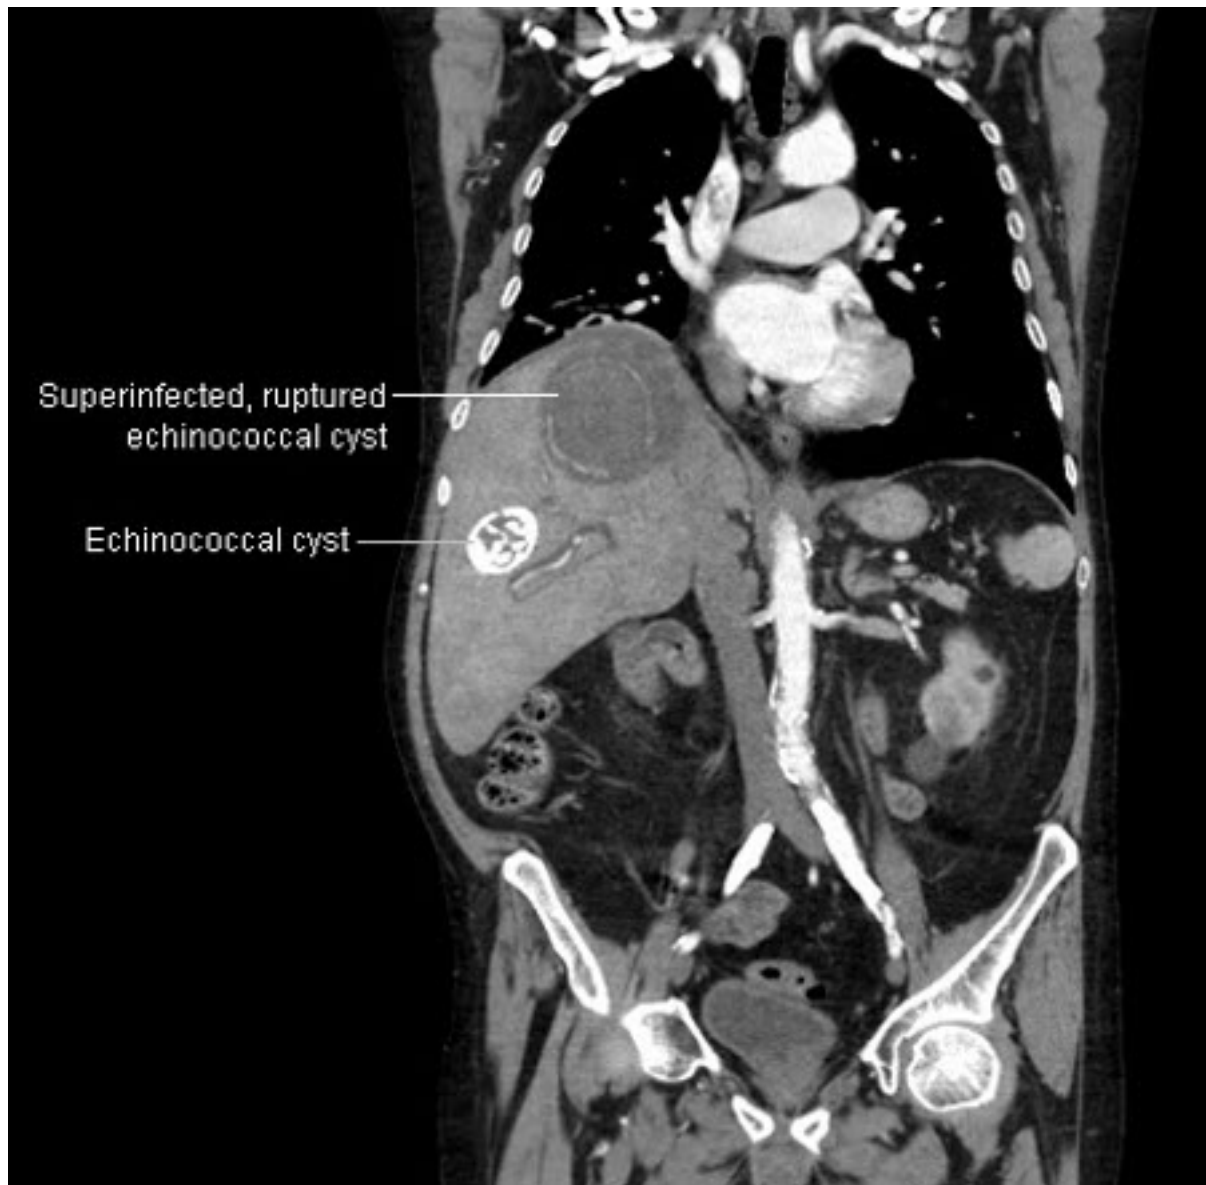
Liver abscess: CT scan showing 8 cm by 8 cm superinfected and ruptured echinococcal cyst, and a 4 cm by 4 cm echinococcal cyst in a 69-year-old man who presented with hypotension and chest pain radiating to the epigastric region
